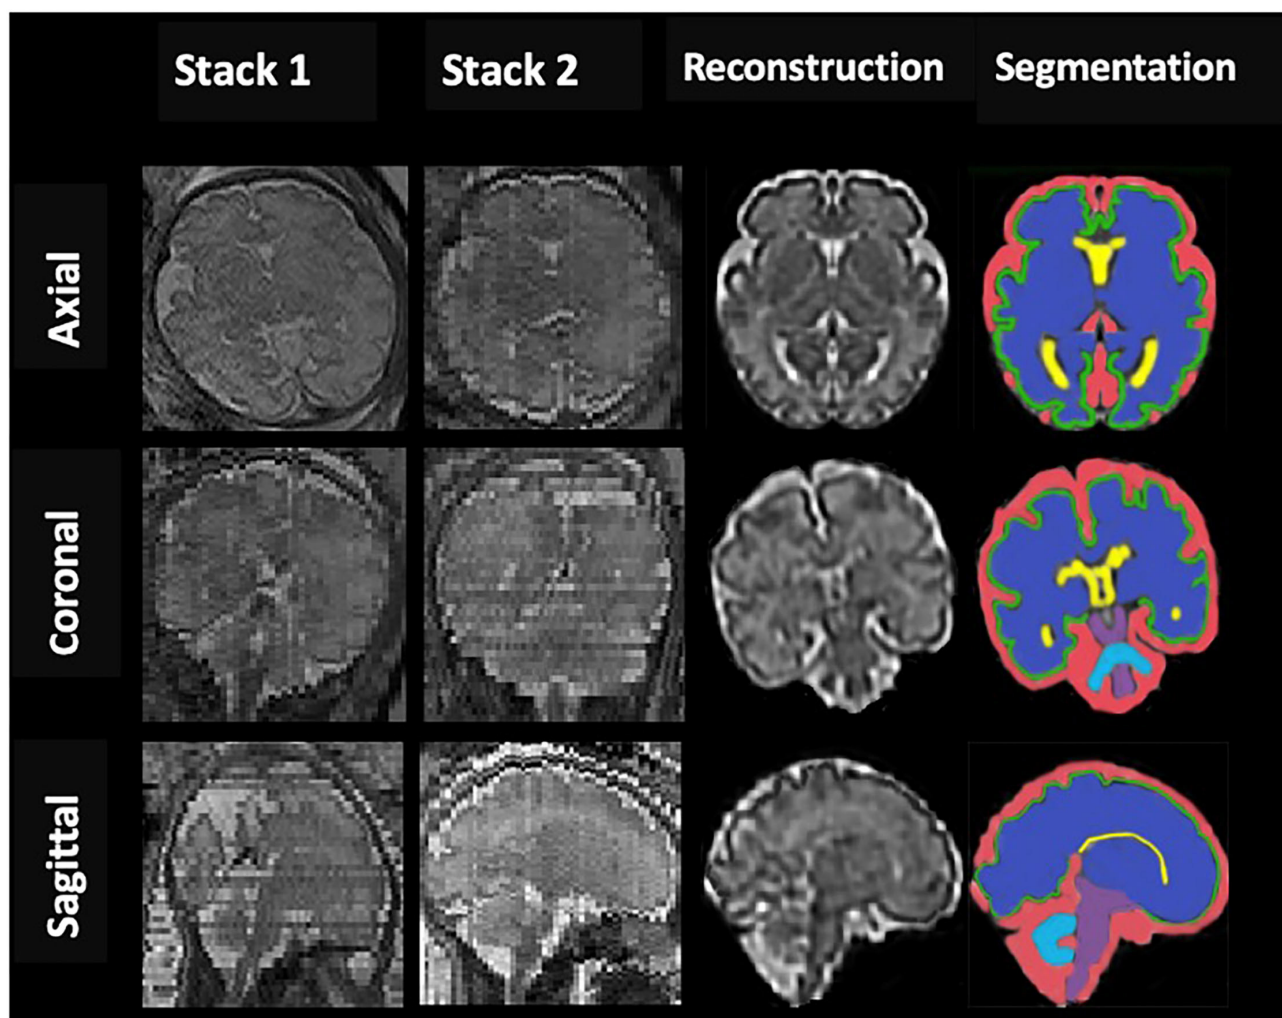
An example of fetal brain reconstruction from two dimensional (2D) single-shot fast spin-echo (SSFSE) MRI slices of axial, sagittal, and coronal planes (Stack1; 2) to a single three dimensional (3D) reconstruction volumetric image (reconstruction column); 3D reconstructed brain of a normal control fetus at 32 gestational weeks with manual 3D segmentations of supratentorial brain tissue, lateral ventricles, cortex, cerebellum, brainstem (BM), and extra-cerebrospinal fluid volume (eCSF) (segmentation column).
